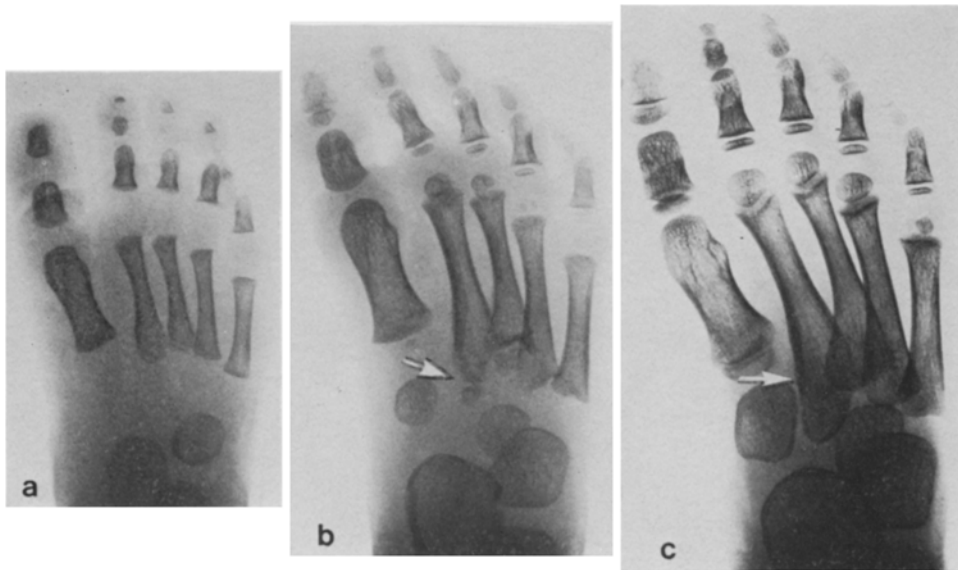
Serial roentgenograms of the right foot of the proband of kindred I. a, at 10 months of age; b, at 3 years of age; c, at 5 years of age.
